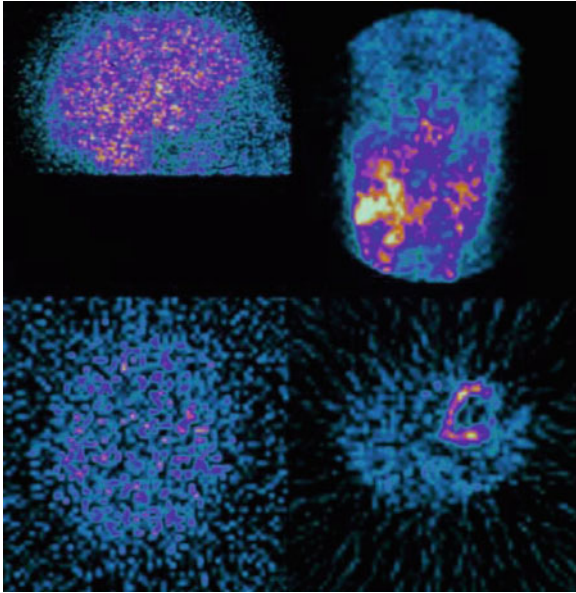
Top left panel* shows one frame from a Brain Perfusion SPECT acquisition, *bottom left* shows the same SPECT acquisition reconstructed with no filtering applied. *Top right* shows one frame from a Myocardial Perfusion SPECT acquisition, *bottom right* shows the same SPECT acquisition reconstructed with no filtering applied
